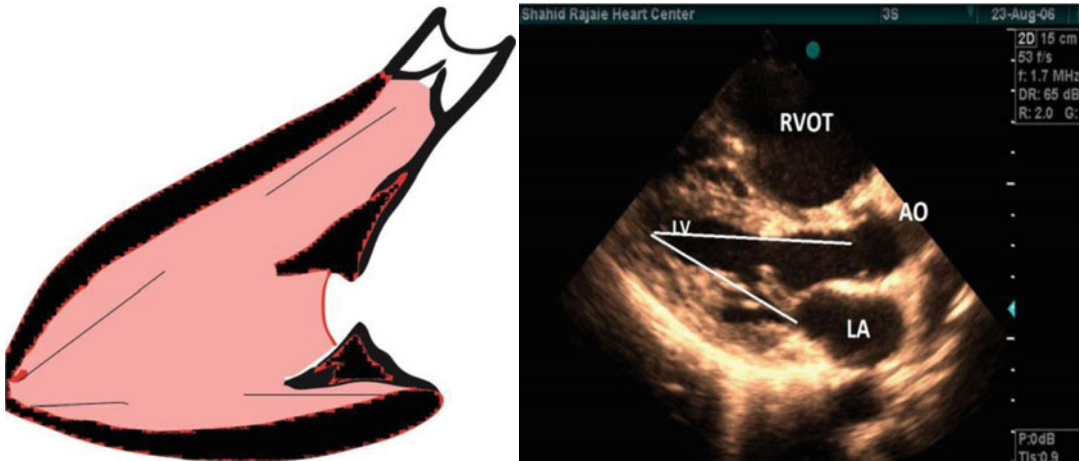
Parasternal long-axis view showing elongated LVOT with shorter distance from MV annulus to LV apex than AV annulus to the apex. AO aorta, LA left atrium, RVOT right ventricular outflow tract, LV left ventricle (LV is right)
